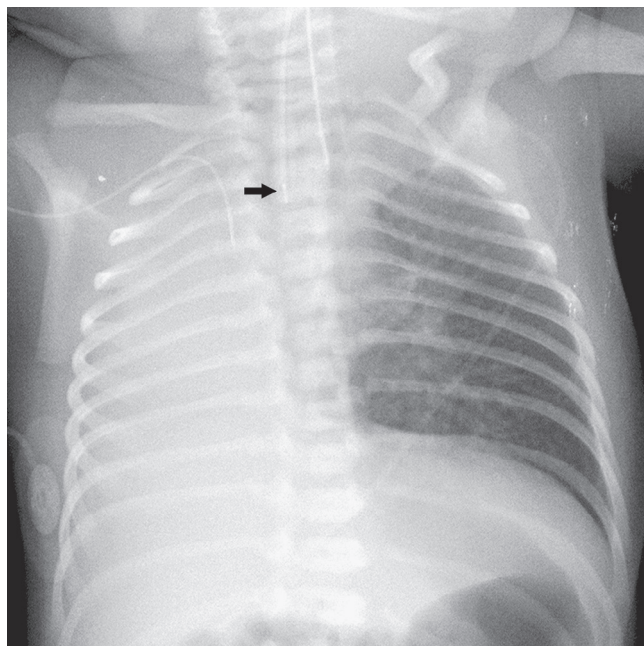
■ Right pulmonary agenesis. Frontal chest radiograph in a newborn with respiratory distress. Note complete opacification of the right hemithorax with mediastinal shift toward the same side. The patient also has esophageal atresia (nasogastric tube lodged in the dilated proximal esophageal pouch, arrow) with distal tracheoesophageal fistula (note air in the stomach). (Courtesy Simon C. Kao, MD, Iowa City, IA.)
